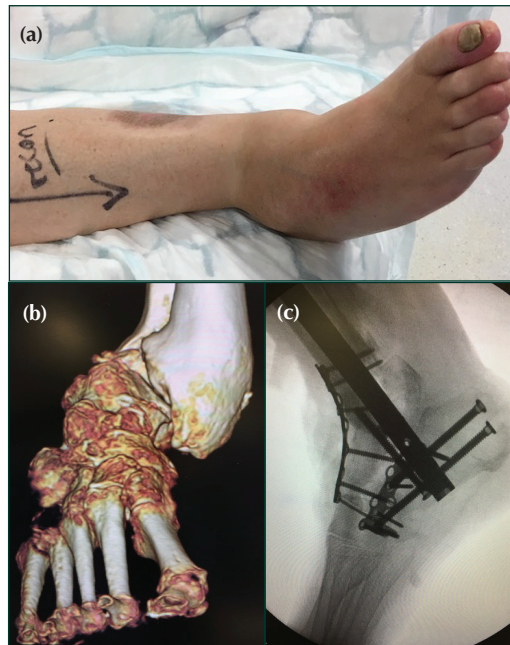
Hindfoot Charcot treated with intramedullary nailing: (a) Clinical photograph showing severe ankle and hindfoot deformity secondary to Charcot neuroarthropathy (b) CT 3 dimensional reconstruction showing bony deformity of hindfoot (c) Intra-op fluoroscopic image showing lateral view of reconstructed hindfoot.
